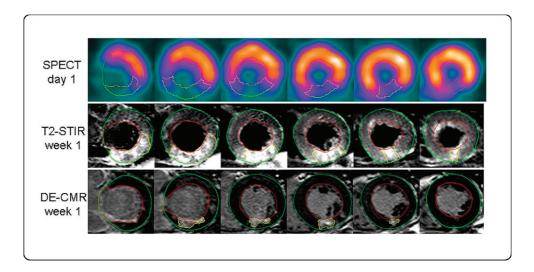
Myocardium at risk by single photon emission computed tomography (*upper panel*) and T2-STIR cardiovascular magnetic resonance (CMR) imaging (*middle panel*) and final infarct size by delayed-enhancement CMR images (*lower panel*) in a patient with acute STEMI who underwent percutaneous coronary intervention. The green line delineates the epicardium and the red line delineates the endocardium. In the middle panel, the myocardium at risk is delineated in yellow. The difference between the myocardium at risk and the final infarct size (delineated in yellow in the images in the lower panel) defines the salvaged myocardium after reperfusion. Myocardium at risk can also be shown as enhanced myocardium in steady-state free precession cine images after gadolinium contrast agent administration [185, 186]. Reprinted with permission from Carlsson et al [182].
